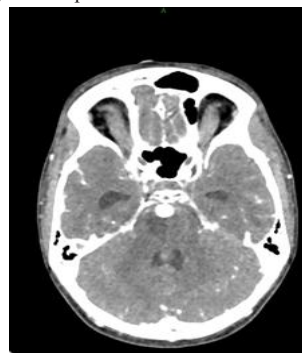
CT Brain Angiography- Arterial phase- Axial Section: rounded or lobulated outpouching on the basilar artery, located at bifurcation- Aneurysmal dilatation.
